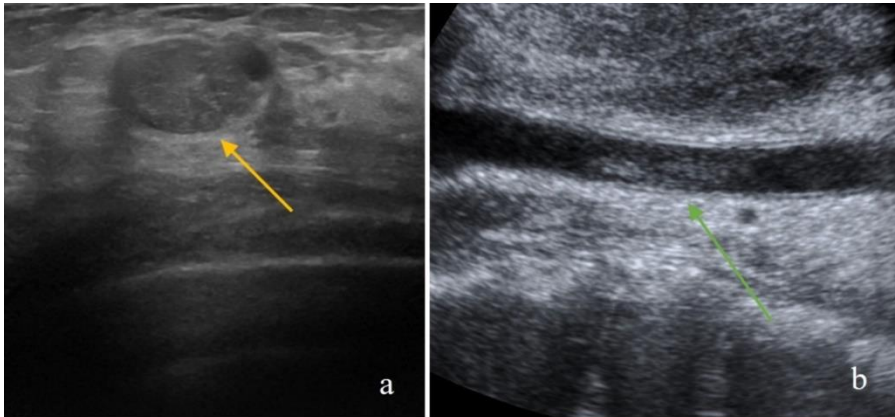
B mode breast ultrasound- isoechoic, macrolobulated, oval shaped inhomogeneous (yellow arrow) fibroadenoma (a); B mode thigh ultrasound femoral vein thrombosis
